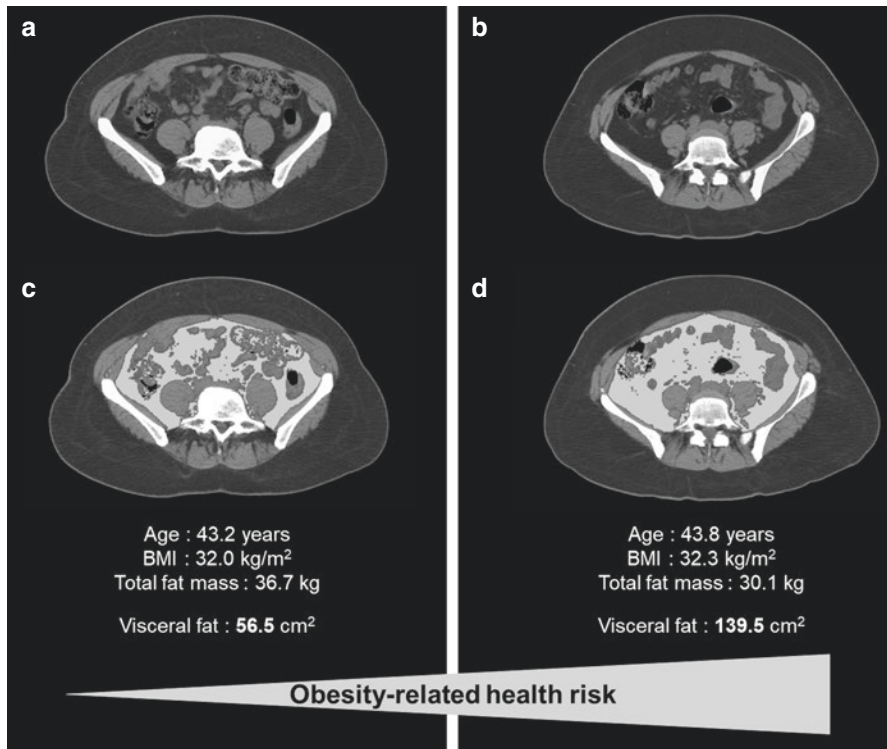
Representation of the obesity-related health risk associated with visceral fat accumulation. Comparison of computed tomography scans from two women with similar age and body mass index (BMI), but showing different visceral adiposity which is higher in b, d compared to a, c despite lower total body fat mass in a, c. Visceral adipose tissue area highlighted in light grey (c vs. d) correlates with increased cardiometabolic risk
